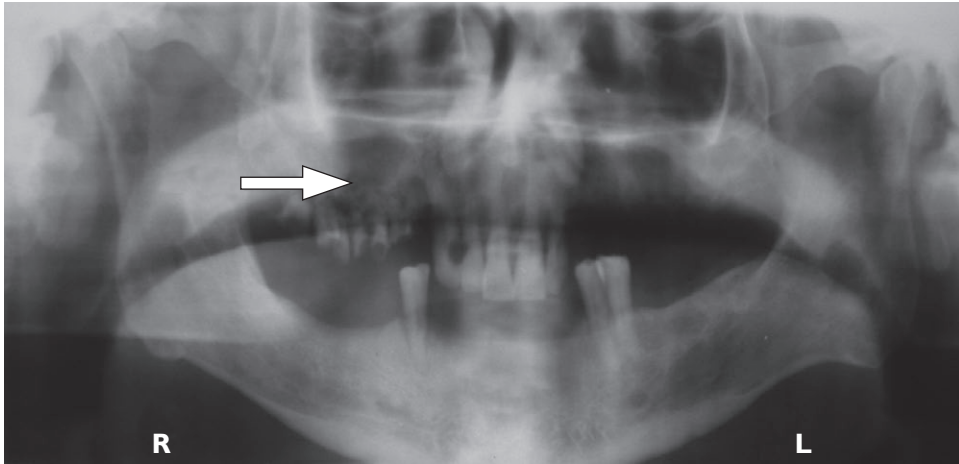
Orthopantomograph showing a well-defined radiolucent oval right side of palate.
